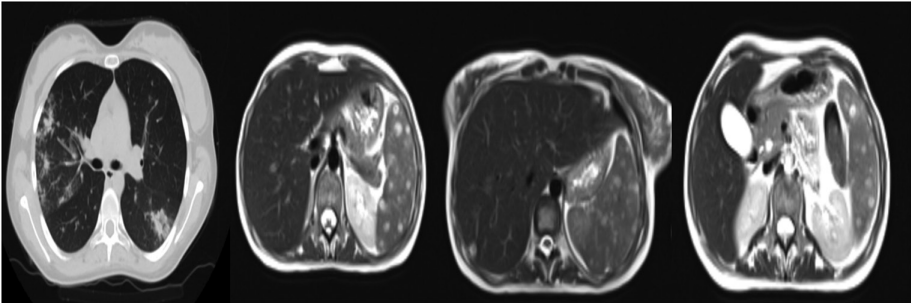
Multiple areas of consolidation and nodular lesions caused by *M. capitatus* in the lung, liver, spleen, kidney, and pancreas at pulmonary tomography and abdominal magnetic resonance imaging.
